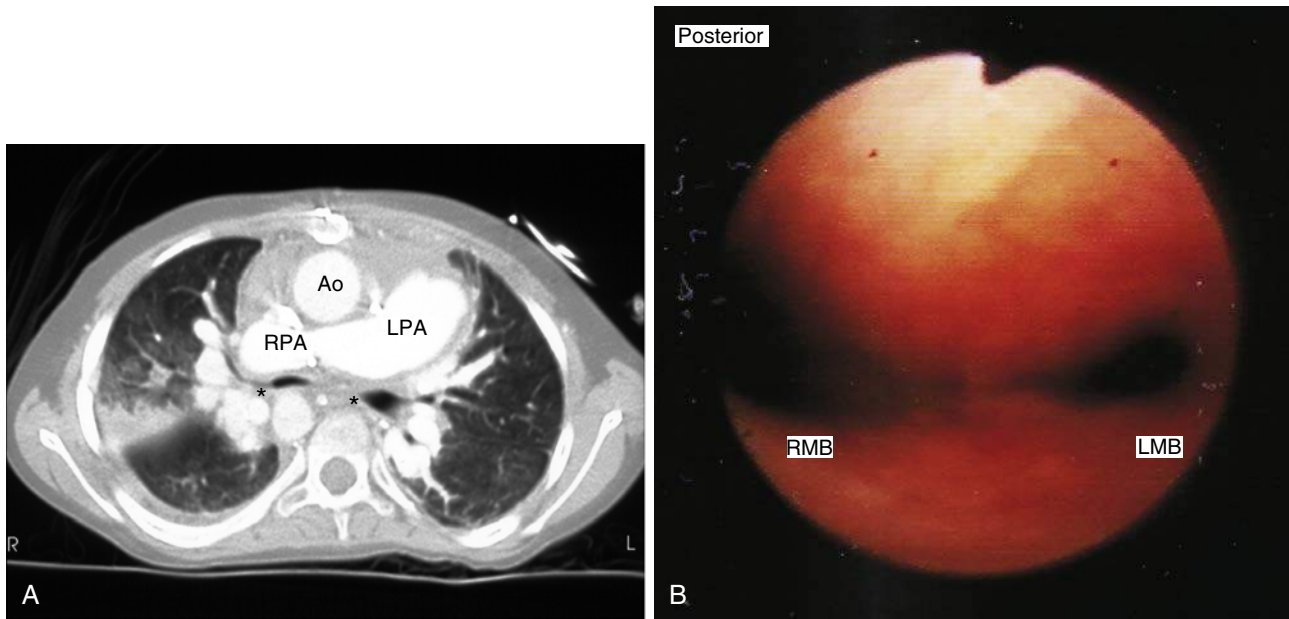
A, Thoracic computed tomography scan of a patient after repair of pulmonary atresia in the setting of a right aortic arch. The bronchi (asterisks) are compressed bilaterally by the left and right pulmonary arteries (LPA, RPA). The ascending aorta (Ao) can be seen anteriorly. B, Bronchoscopic examination of the same patient. Bilateral compression of the bronchi to slit-like structures can clearly be seen. Ao, Ascending aorta; LPA, left pulmonary artery; LMB, left main bronchus; RMB, right main bronchus; RPA, right pulmonary artery.
